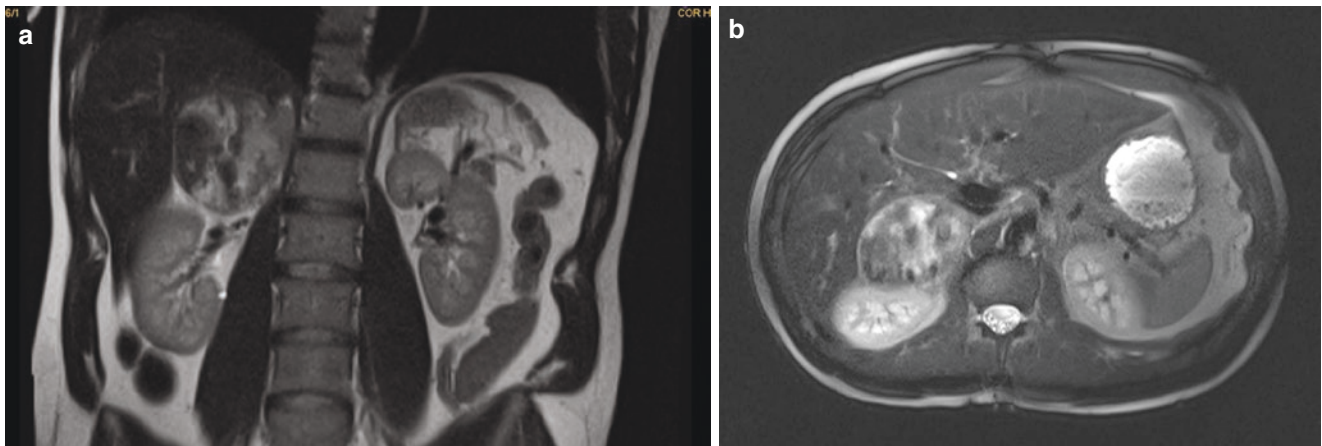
(a, b) Indication for surgery: a 33-year-old man with type 1 cutaneous neurofibromatosis presenting with 1-year history of hypertensive episodes and 10-cm right adrenal mass on magnetic resonance imaging (MRI). Biochemical testing revealed elevated normetanephrines and metanephrines. Contralateral adrenal gland was normal, and there was no evidence of extra-adrenal lesions suggestive of paraganglioma. Neurofibromatosis confers increase in risk of paraganglioma
